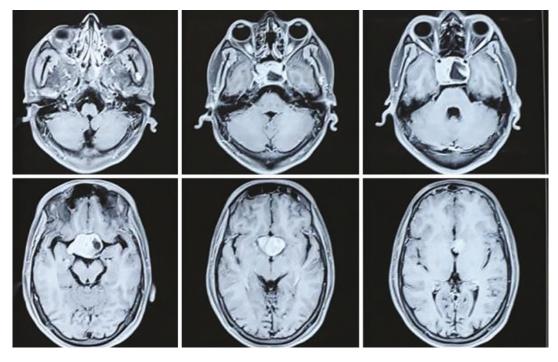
MRI brain axial section showing a pituitary tumour
